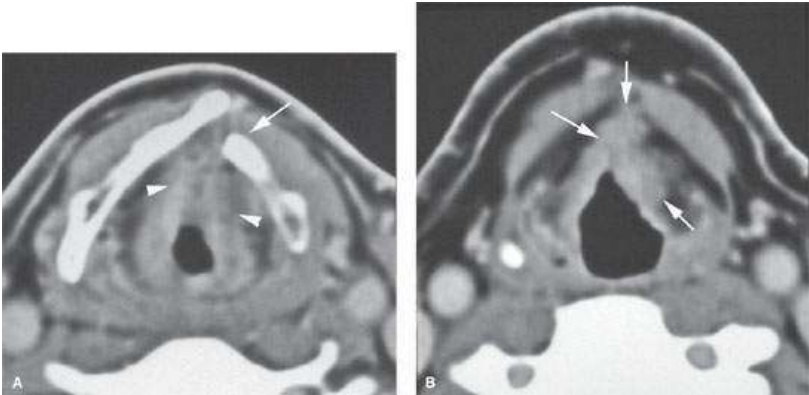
Contrast-enhanced computed tomography study of patient with pain several years after partial laryngectomy for vocal cord carcinoma. No baseline study was available. A: Deformity of the laryngeal skeleton (arrow) consistent with that seen in vertical hemilaryngectomy is present. Soft tissue changes at the level of the reconstructed vocal cords are nonspecific (arrowheads). B: While the soft tissue findings in (A) were not specific, those in this image show obviously infiltrating tumor in the pre-epiglottic space (arrows). The patient was salvaged with total laryngectomy, and extensive recurrent tumor was confirmed.
